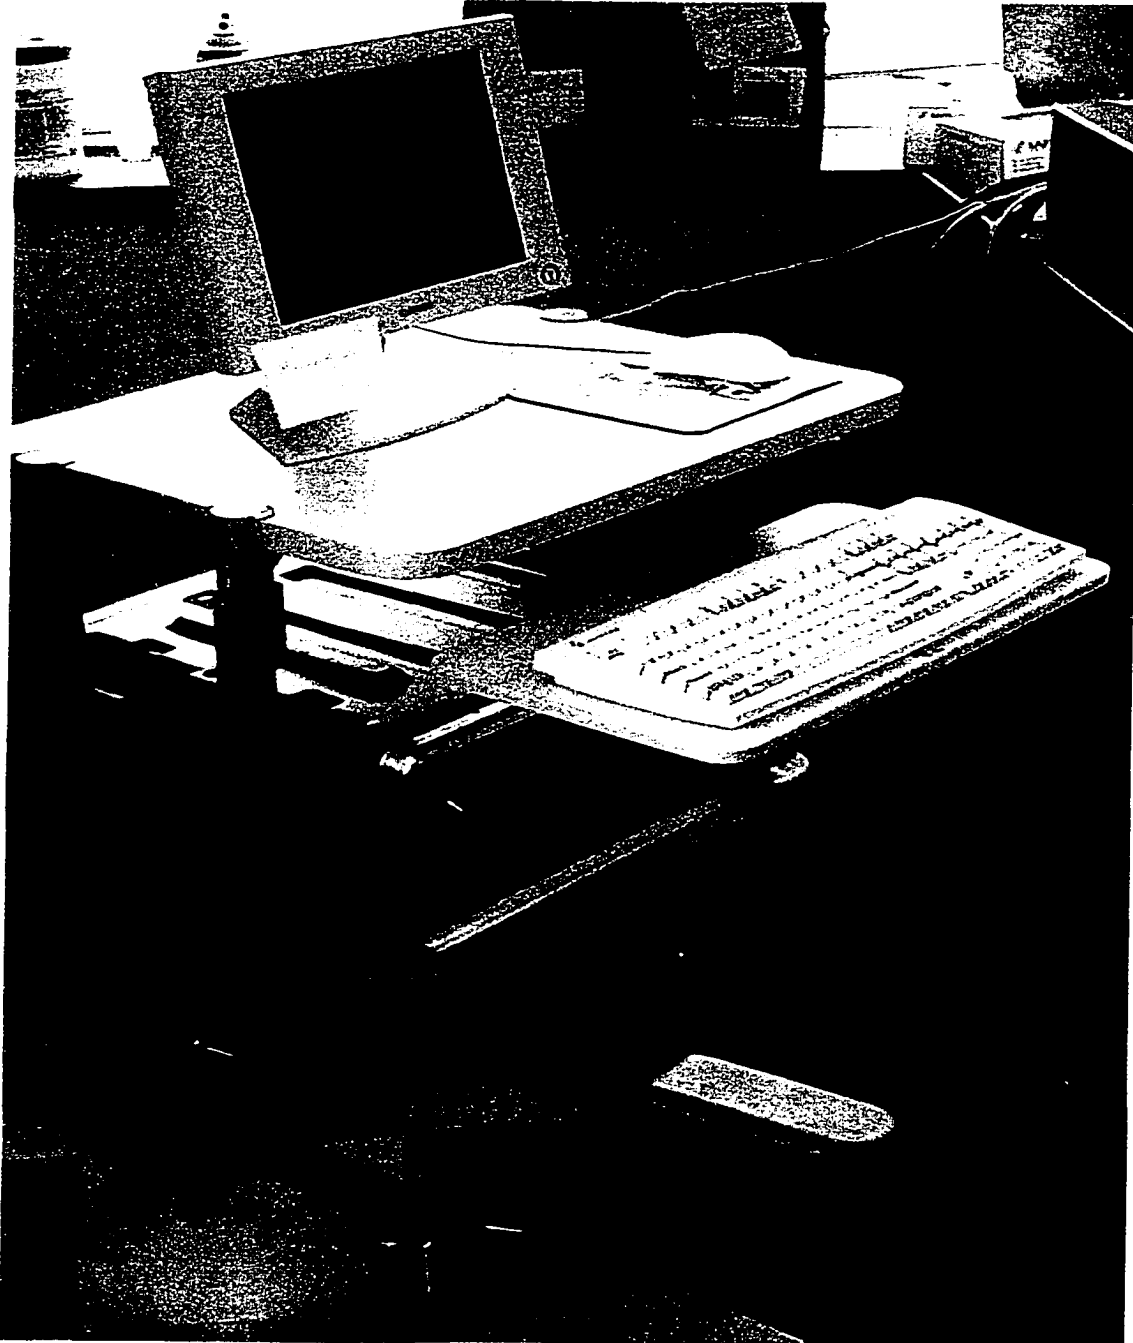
Rackmount computer system used to run the ultrasonographic periodontal probe.
